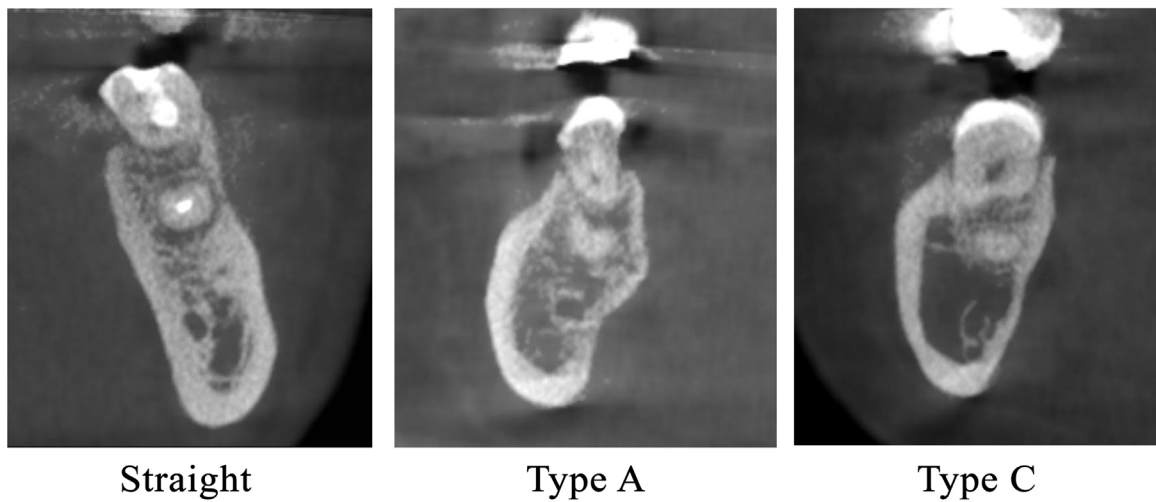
CBCT image of the mandible showing the different types of the mandible according to its shape in coronal sections. Type A (rounded buccal side and concave lingual side), type C (rounded on both sides) and straight.
